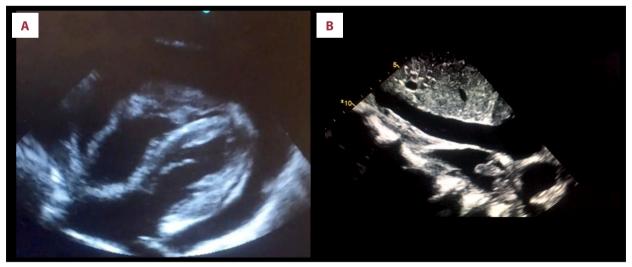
The initial bedside echocardiogram showing large-volume pericardial effusion with diastolic collapse of the right ventricle (A) and noncollapsing inferior vena cava despite volume depletion due to pericardial tamponade and blood shunting resulting from superior vena cava occlusion (B).
